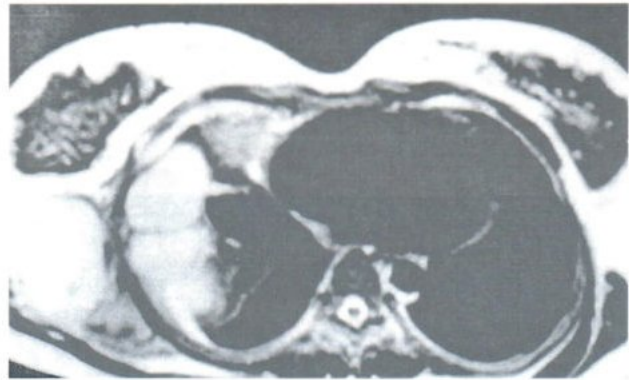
Axial MRI of the chest in T1W with Gd enhancement disclosed markedly homogenous enhanced mass.
